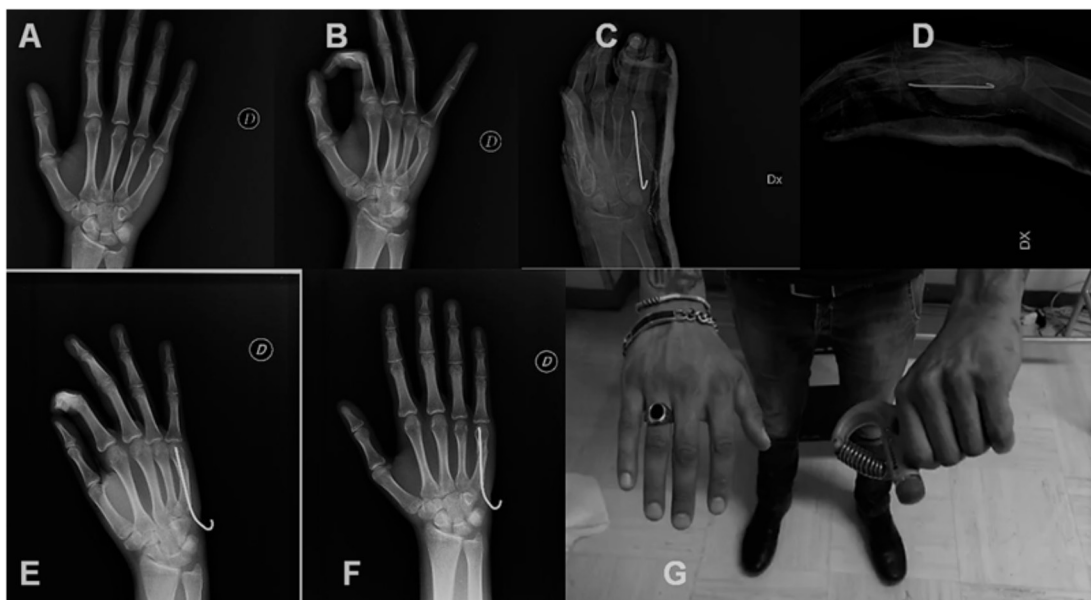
An 18-year-old male with transverse fracture of the right V metacarpus from bike fall. A, B) Pre-operative X-rays show the above fracture in detail; C-D) postoperative X-rays show the surgical treatment with plate and screws; E-F) control X-rays at 6 months; G) result in the grip test at 6 months (Pasquino A, 2017)
